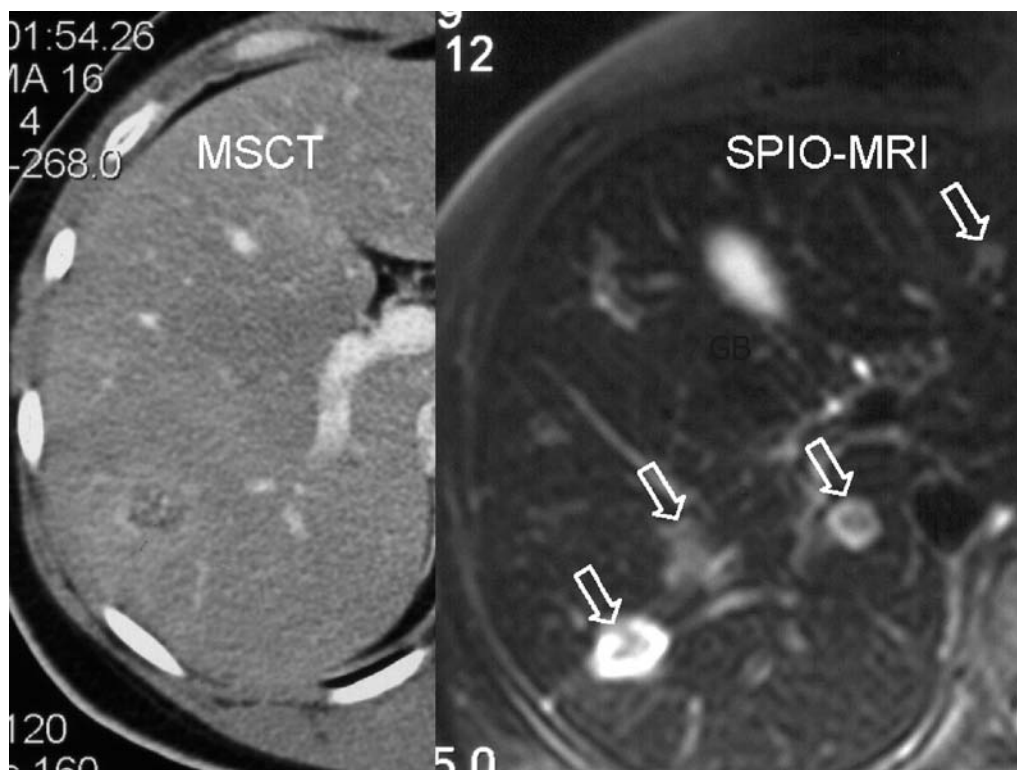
CT and SPIO-MRI of a patient with liver metastases evaluated for minimally invasive tumor therapies. While CT shows poor visualization of liver metastases, MRI using SPIO as liver-specific contrast media demonstrates clearly four hyperintense liver lesions (GB: gallbladder)
